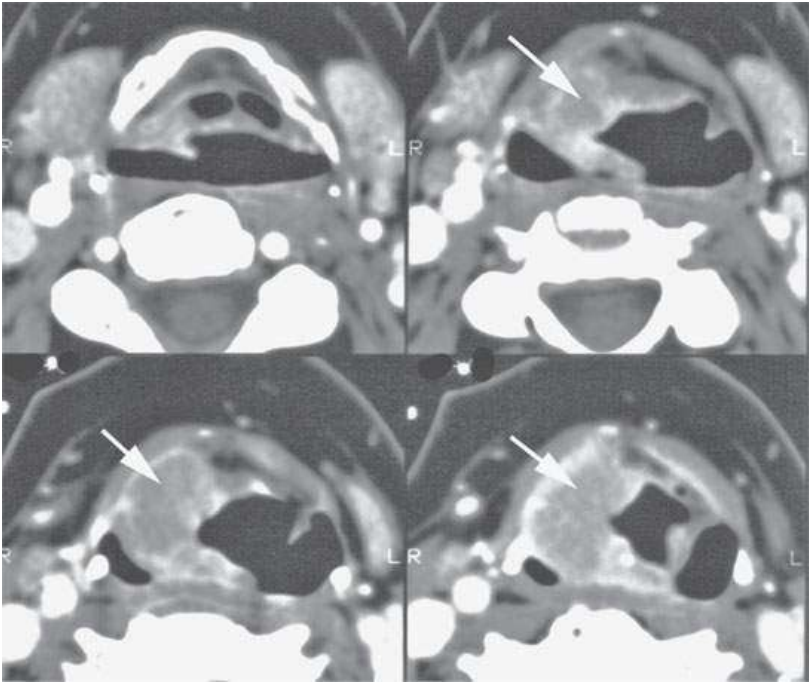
Contrast-enhanced computed tomography (CT) of the larynx in a patient with submucosal supraglottic cancer not visible to the endoscopist, the patient presenting with hoarseness and right-sided otalgia. This mass (*arrows*) was likely present for 2 years before a percutaneous CT-guided biopsy, following three negative endoscopic biopsy attempts, confirmed squamous cell carcinoma.
